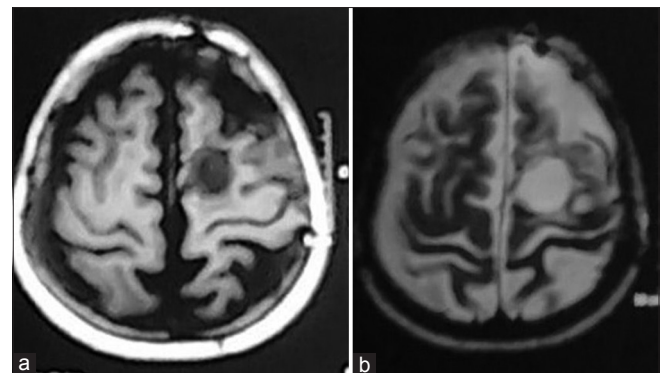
Magnetic resonance imaging of the brain at 6 months follow-up does not reveal any signs of recurrence on T1-weighted imaging (T1-WI) and T2-WI (a and b)
